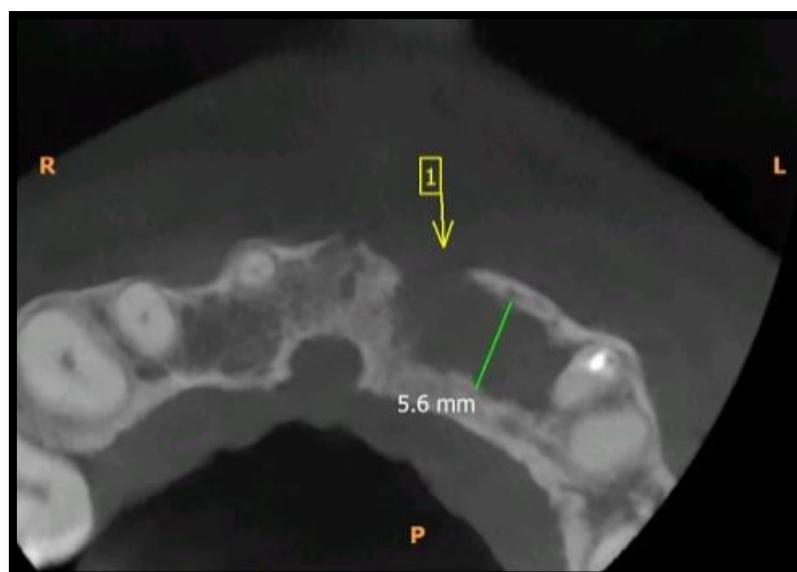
CBCT scan showing buccal cortical bone loss along with width defect due to radicular cyst at periapical area.
